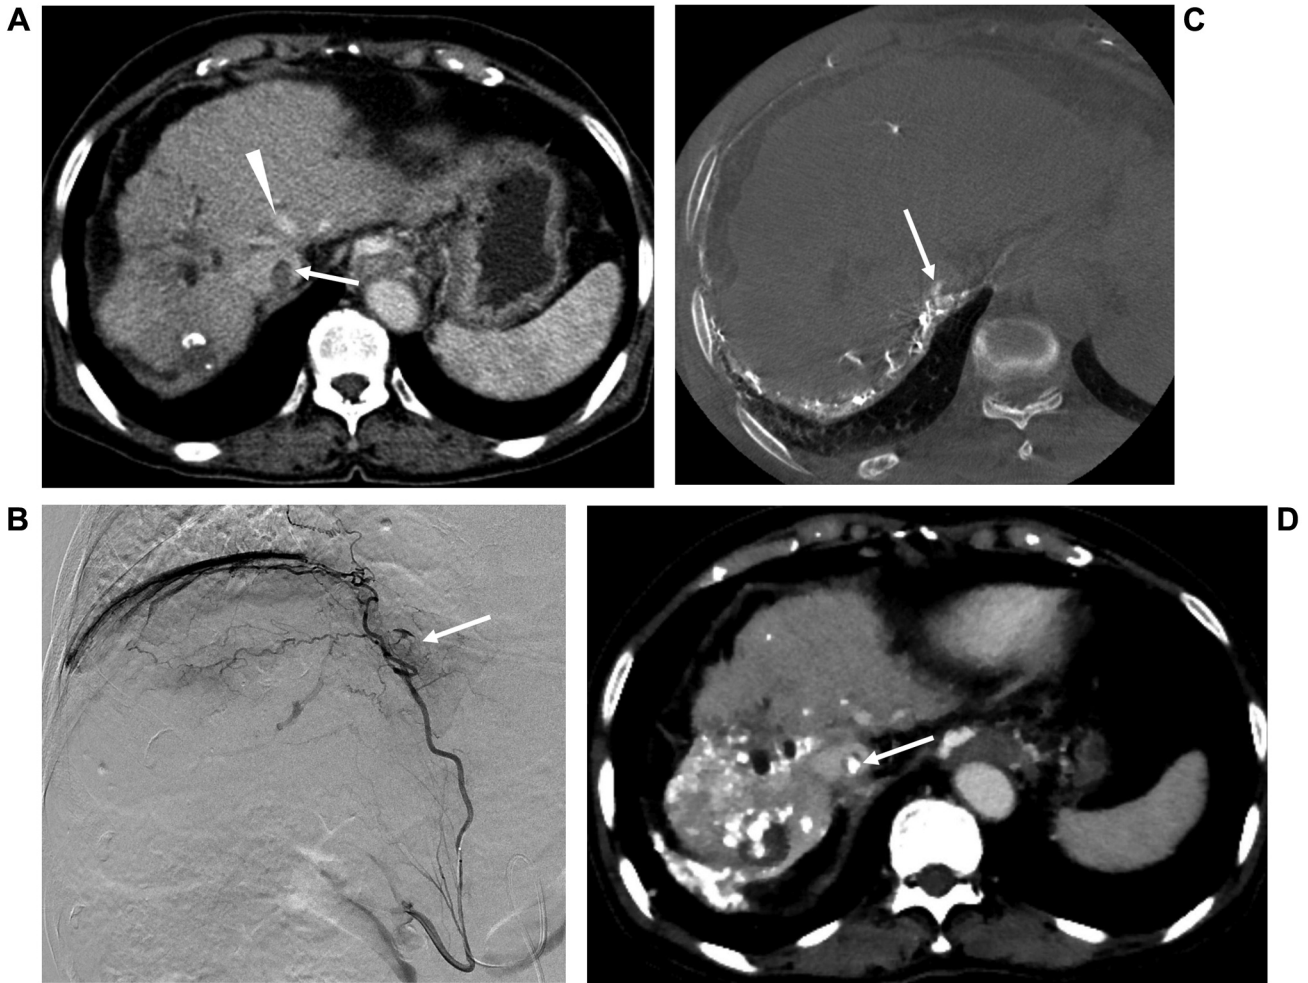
An 80-year-old woman (patient number 6) with hepatocellular carcinoma. A: Computed tomography (CT) scan showed a small thrombus (arrow) in the inferior vena cava (IVC) below the hepatic vein confluence. Note the patent hepatic vein (arrowhead). B: Right inferior phrenic angiogram showing tumor blush (arrow). C: Axial image of cone beam CT of the right inferior phrenic artery showing enhancement of a tumor thrombus (arrow). D: CT scan 1 month after chemoembolization showing partial accumulation of iodized oil in a thrombus (arrow).
